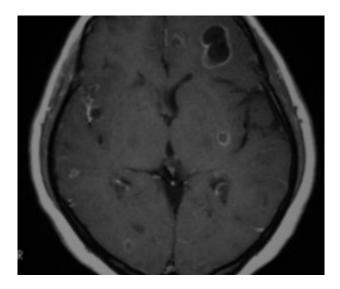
Multiple ring enhancing lesions in Colloid Vesicular Stage of NCC¹⁰⁰ MRI Brain T1W Post Contrast Image shows multiple ring enhancing lesions in Colloid Vesicular Stage of NCC
